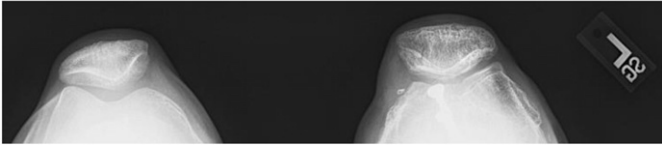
Merchant view radiographs demonstrate the alignment of the patella following tibial tubercle osteotomy and transfer.
